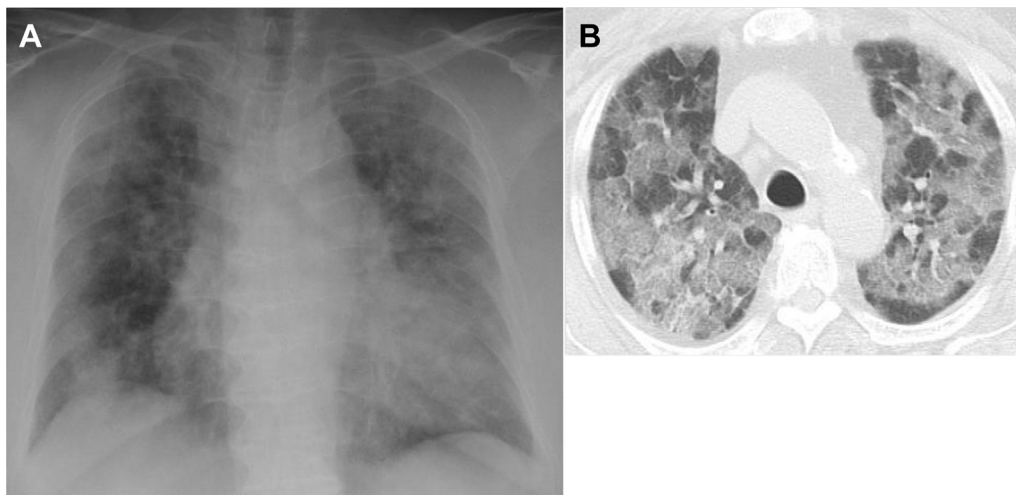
A, Chest radiograph on admission showed bilateral patchy opacities distributed predominantly in the upper lung fields. Pleural effusion and lymphadenopathy were not observed. B, Chest CT image on admission showed multifocal segmental and subsegmental ground-glass opacities, bronchial wall thickening, and interlobular septal thickening but no pleural effusion or lymphadenopathy.
